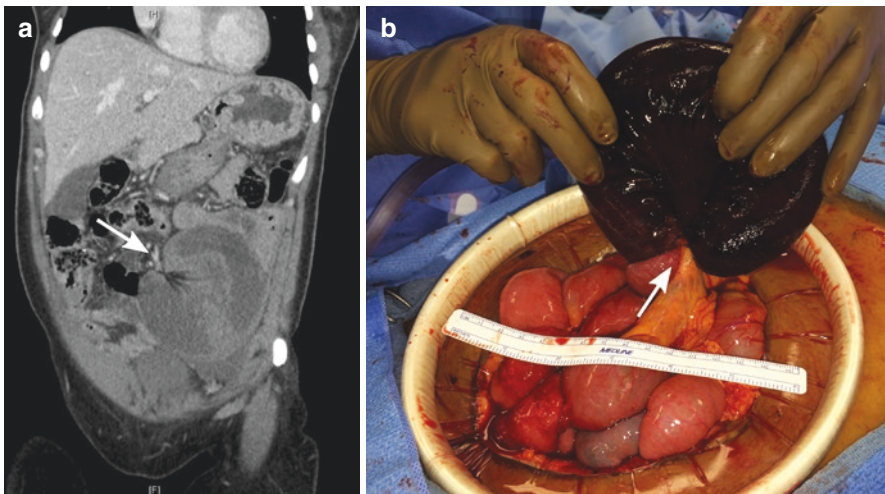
(a, b) Abdominal CT scan images and operative findings in a woman with an adhesive closed loop small bowel obstruction after low-anterior resection for rectal cancer. Given the CT findings and peritonitis on exam, the patient was felt to be a poor candidate for laparoscopic exploration and underwent laparotomy and small bowel resection. a shows a coronal image with a class C-shaped closed loop obstruction with thickening and hypoenhancement of the bowel wall as well as edema and lack of perfusion in the associated mesentery. The arrow points to the location of both proximal and distal obstruction. b shows findings on exploratory laparotomy, with internal hernia through a short adhesive band causing closed loop obstruction and ischemia of a loop of small intestine
